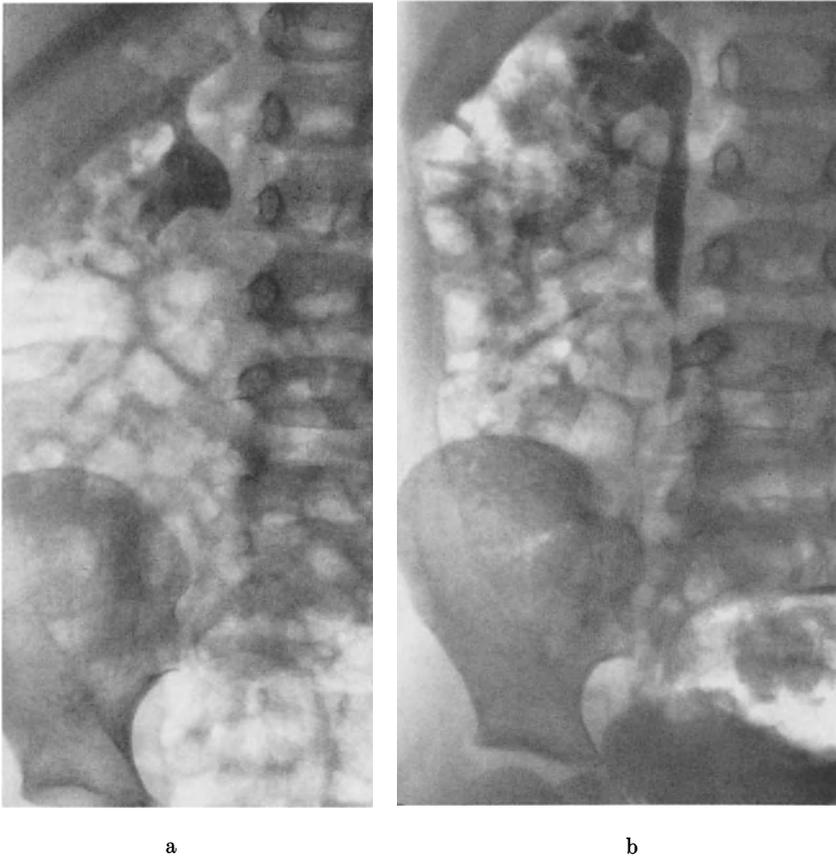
a and b. Infective renal calculus. a Straight X-ray. b Intravenous urogram showing ureteric dilatation without either obstruction or reflux
